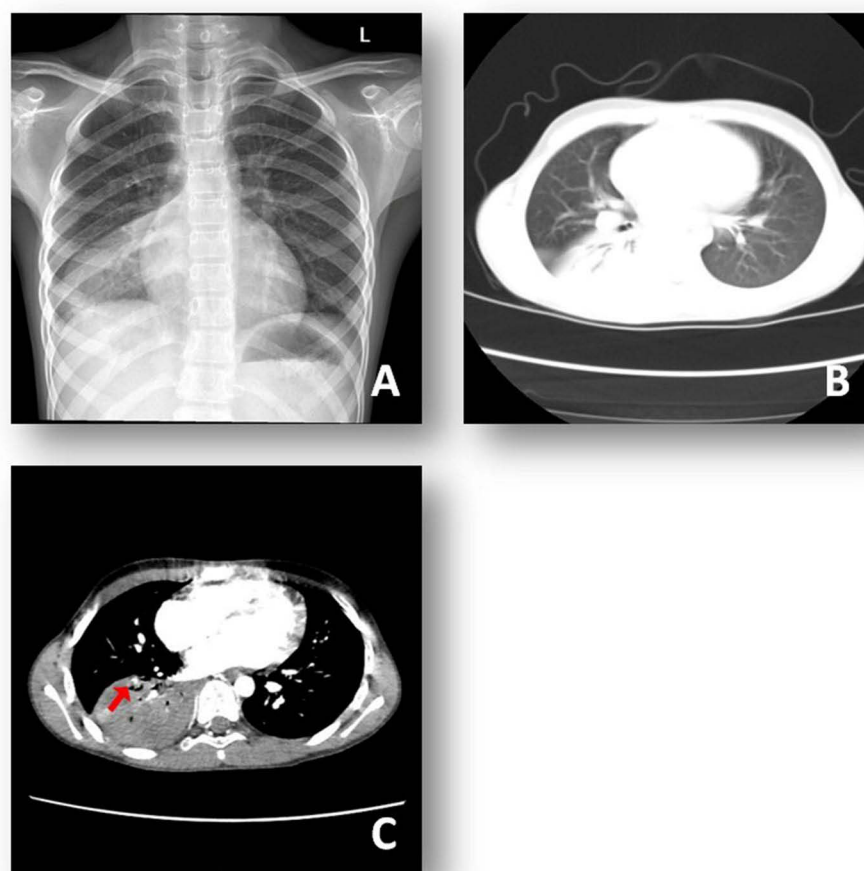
Chest X-ray showed right side pneumonia (A) Chest CT showed consolidation of the lower lobe of the right lung (B) Chest CTA showed a filling defect (red arrow) in the right lower pulmonary artery (C).
